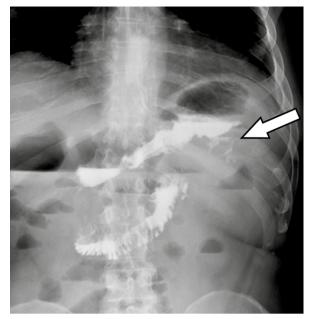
Computed tomography image of the abdomen, revealing the presence of a fistula to the tumor mass (arrow)
